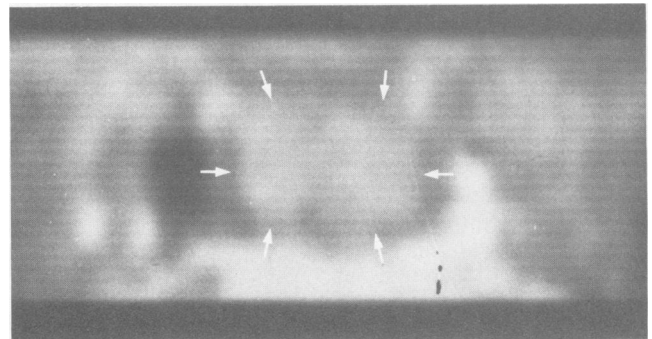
Computed tomography of the head with intrathecal administration of metrizamide. Shown is a coronal computer reconstruction of the sellar area. Metrizamide (hyperdense area outlined by arrows) completely fills the sella, confirming the presence of an empty sella. The hypodense area to the left is a pneumatized sphenoid sinus.
